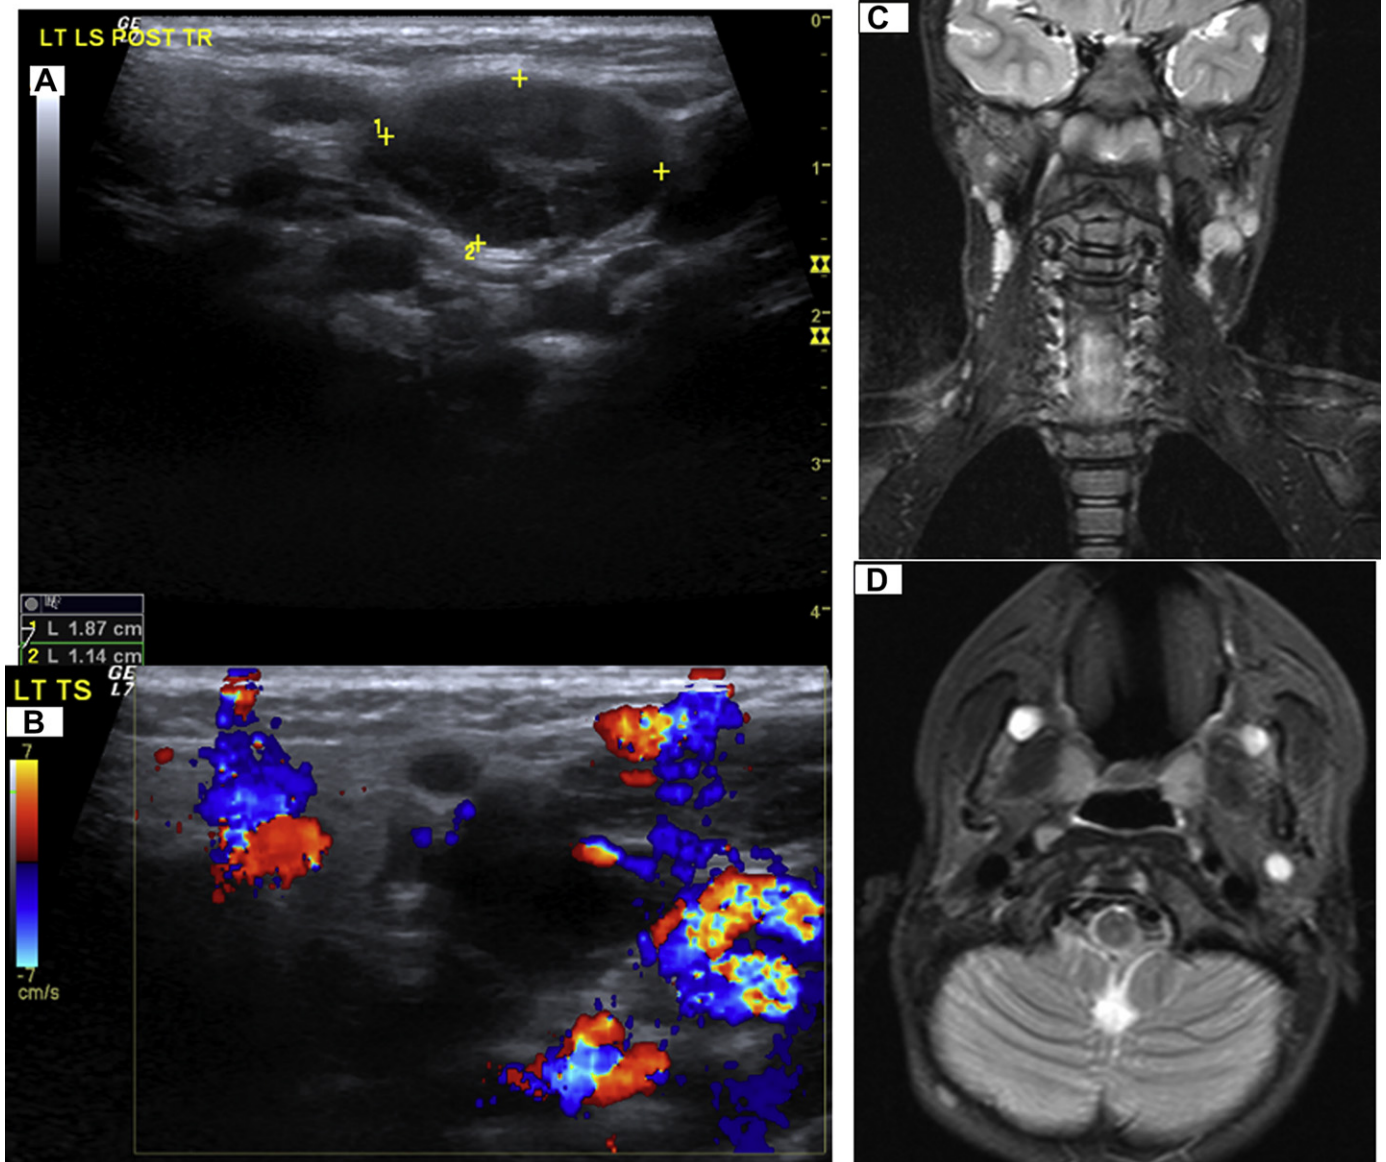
A, Ultrasound 2B Color Doppler and; C&D, MRI scans showing the location and extent of the sinus and the cyst.
